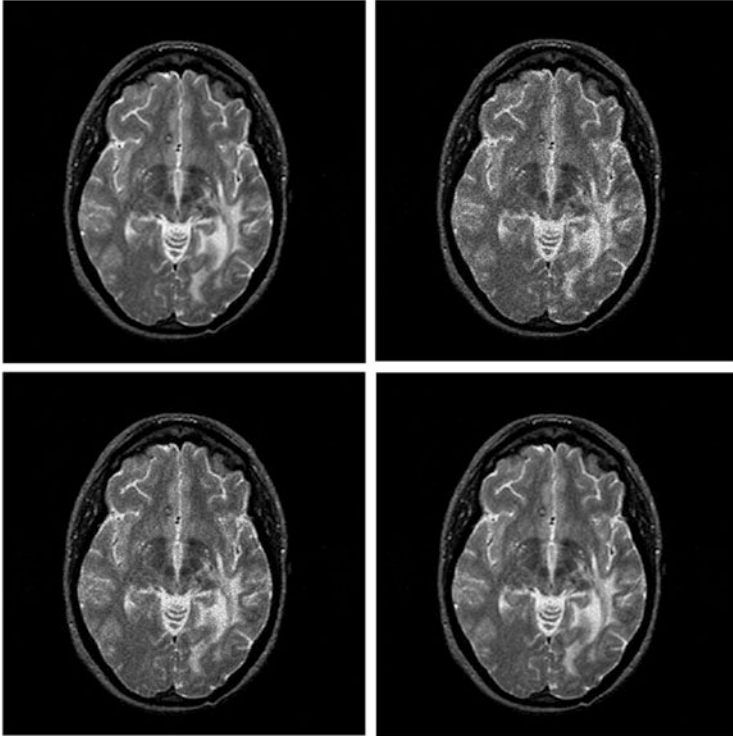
Applying hybrid watermarking scheme on the MR image; from up to down and from left to right respectively: original image, watermarked image with DWT-SVD method (PSNR and NC values are 26.44 dB and 0.88 respectively), watermarked image with DWT-SVD process and WOA (PSNR and NC values are 39.08 and 0.95 respectively) and watermarked image with DWT-SVD method and optimized WOA (PSNR and NC values are 43.64 and 0.97 respectively)
